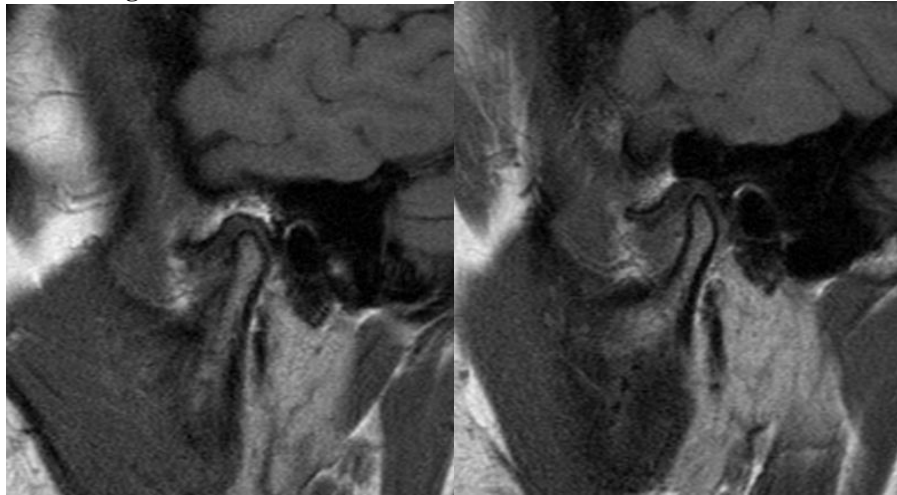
Post-Treatment Sagittal T1 Weighted MRI in closed mouth position shows right (a) and left (b) TMJ anterior disc displacement
